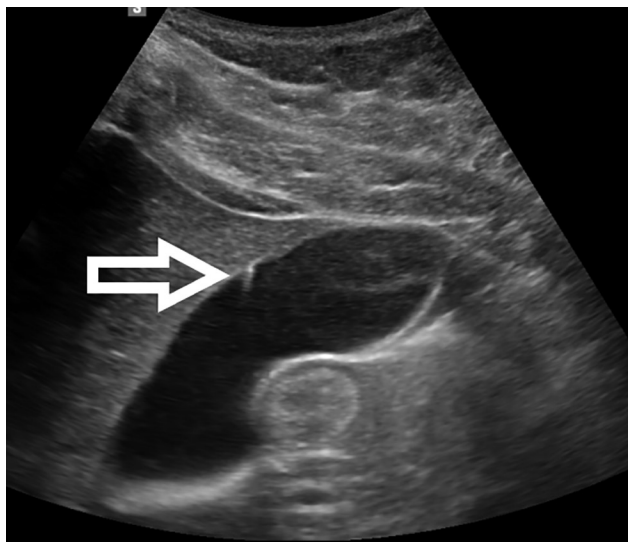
Comet tails on abdominal ultrasound.
